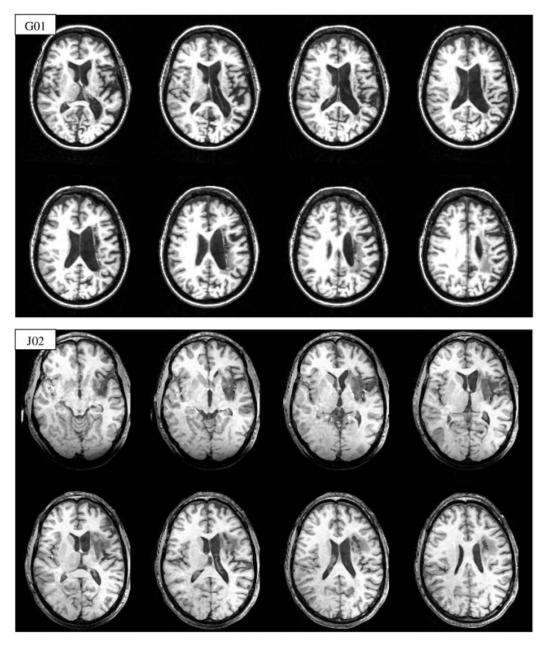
T1-weighted axial magnetic resonance images in radiologic space (left is on the right) showing the extent of left cerebral vascular infarction for G01 and J02.
